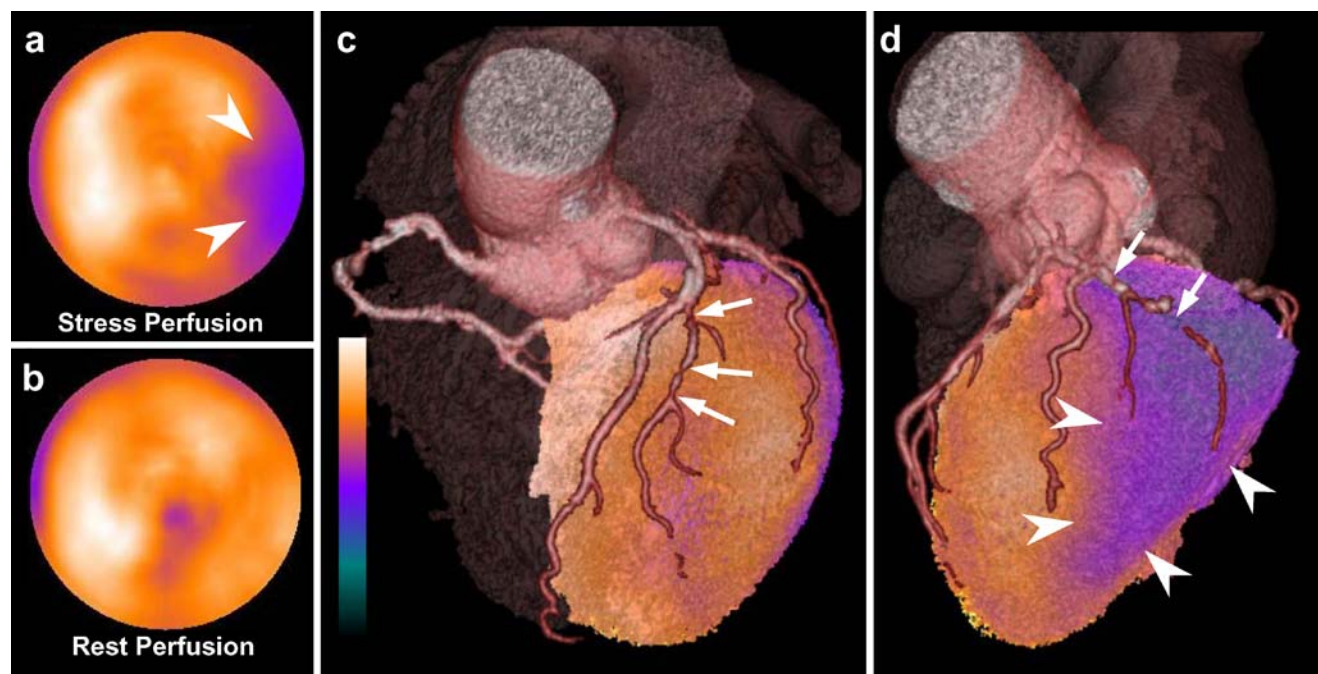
a, b Semiquantitative polar maps of perfusion during vasodilator stress (a) and at rest (b), showing a reversible perfusion defect at the lateral base (*arrowheads*). For presentation purposes, functional (MPI) and morphological (CTA) information was fused, generating three-dimensional (3D) volume-rendered SPECT/CT images. c Anterior view of fused 3D SPECT-CT images showing
